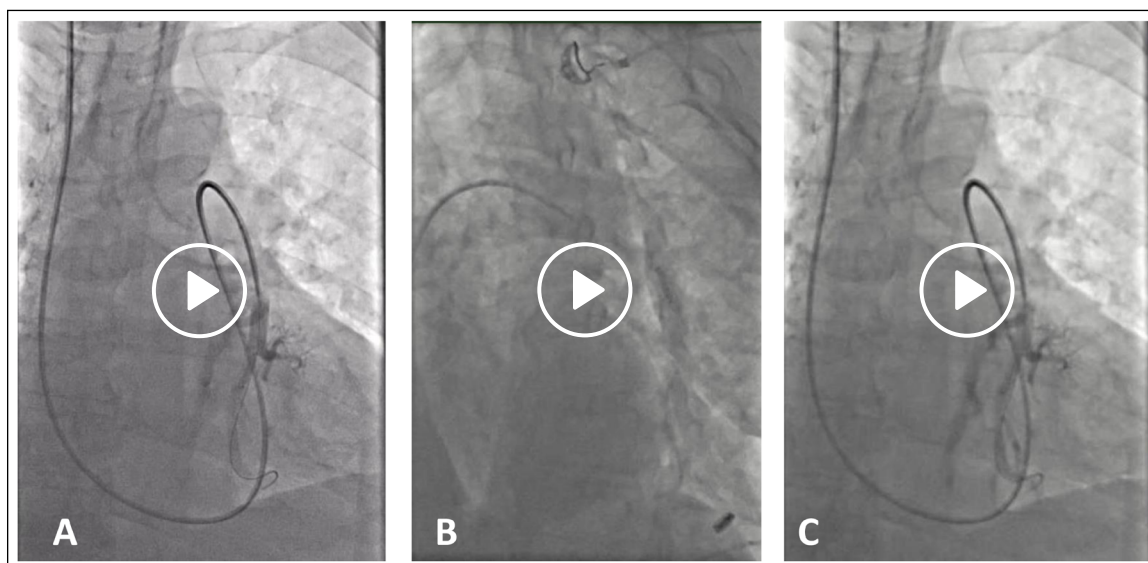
(A) Deployment of the CardioMEMS™ device (Abbott) in a distal left pulmonary artery branch. (B) Post-procedural chest x-ray shows the CardioMEMS™ device in the right middle pulmonary lobe. (C) CardioMEMS™ device found re-embolized to the left lobe, in a proximal left pulmonary artery. (D) Chest x-ray shows the CardioMEMS™ device in place in the lower left lobe months after the procedure.
